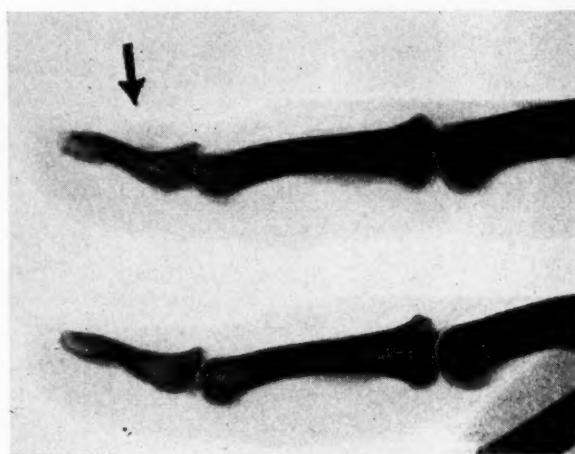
Case 2. Roentgenograms. Comparison of terminal phalanx of involved right middle finger (above) with corresponding one of the other hand. Arrow points to the cupping of the dorsal aspect of the phalanx due to pressure from glomus tumor under the root of nail.
